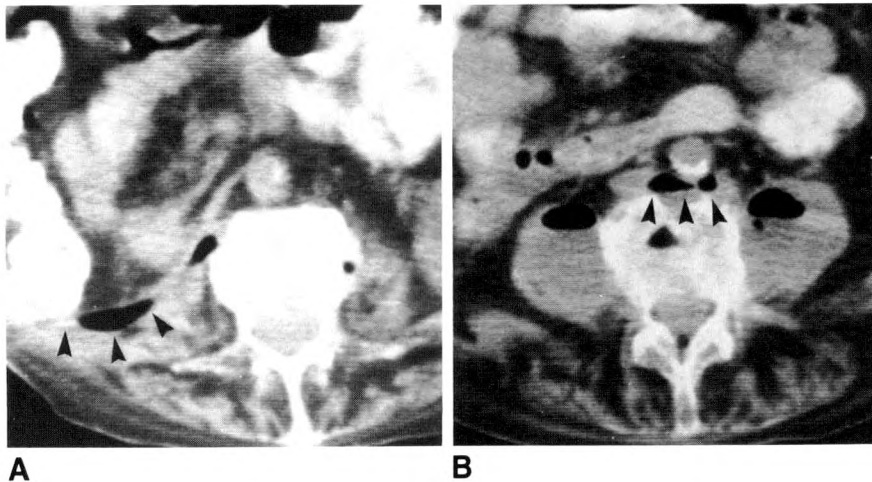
A, CT at level of renal hilus shows gas (arrowheads) extending from nephrectomy incision into right renal fossa and both psoas muscles.
